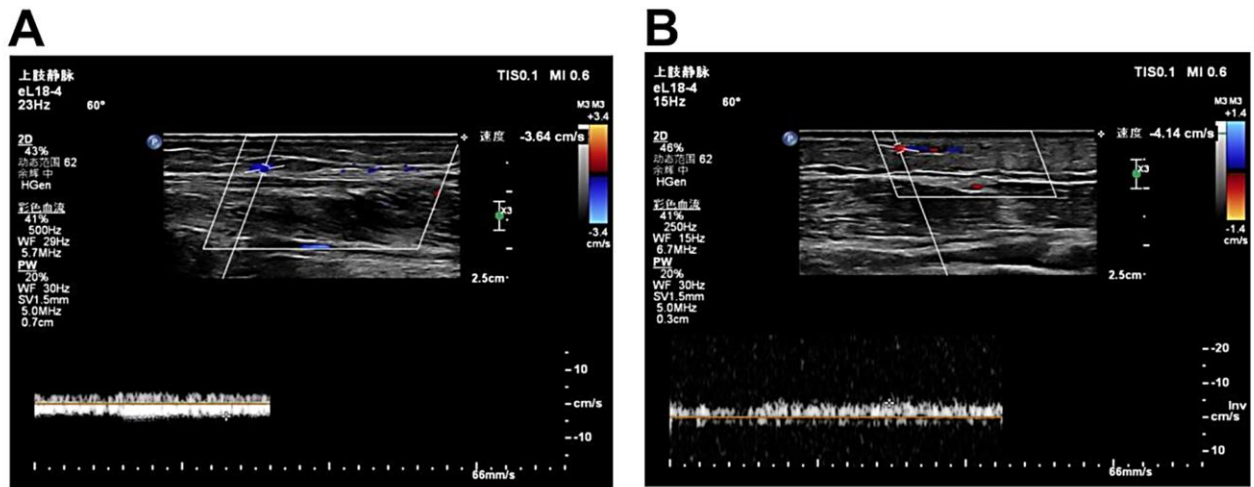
Color Doppler ultrasound findings of venous repair after removal of peripheral venous indwelling needles. (A) Within 24 h after needle removal, there was thrombosis in the vein and the blood flow velocity was 3.64 cm/s. Moderate venous injury was diagnosed. (B) On day 4 after needle removal, there was no thrombus in the vein and the blood flow velocity was 4.14 cm/s, suggesting repair of the vein.
